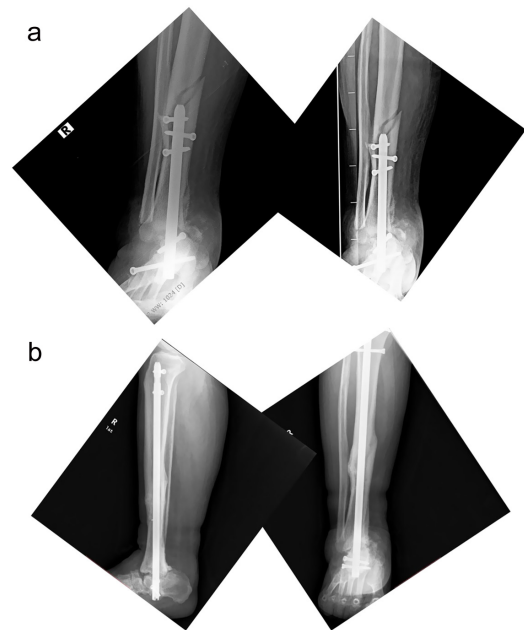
58 years old male; (a) His preoperative radiographies revealing stress fracture and (b) 1 year after revision with a custom-made intramedullary nail.
